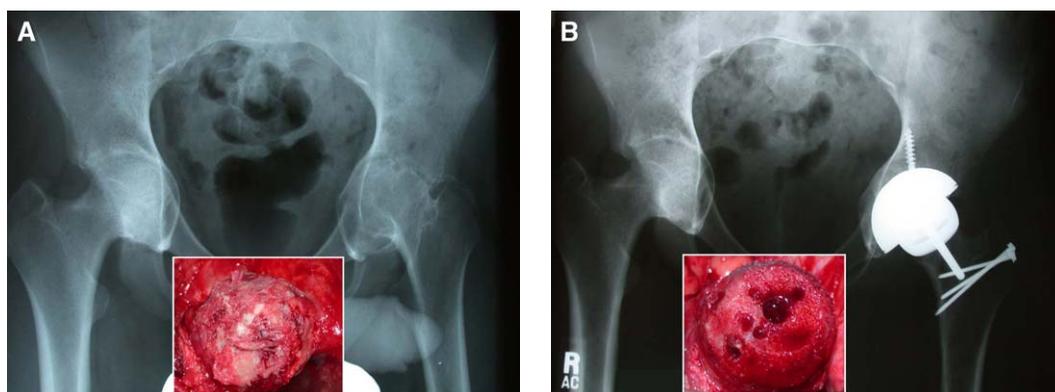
(A) Anteroposterior radiograph showing the protrusio deformity and destruction of the left hip joint. Inset is an intraoperative picture of the femoral head. (B) One-year postoperative anteroposterior radiograph showing a well-fixed hybrid metal-on-polyethylene hip resurfacing arthroplasty. Inset photograph shows the femoral head after preparation. The acetabulum was reconstructed with a modular cementless shell (58-mm outside diameter; Trabecular Metal Cup, Zimmer, Warsaw, IN) and a highly cross-linked polyethylene (40-mm inner diameter; Longevity, Zimmer).
